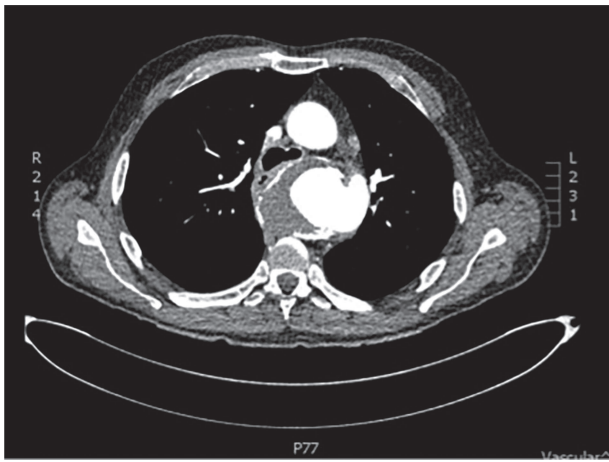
CT scan demonstrating close relationship of oesophagus and aortic aneurysm sac.
